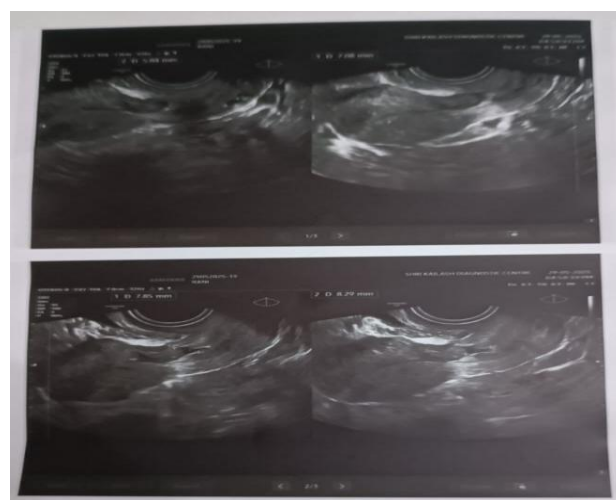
Follow-up transvaginal ultrasonography after medical management.
